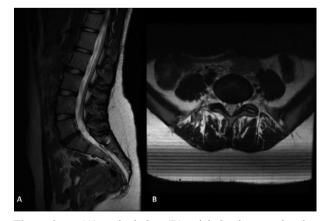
(A) sagittal t2w, (B) axial t2w images showing lumbar (spinal) MRI of the patient with central protrude herniation at L5-S1 level.
